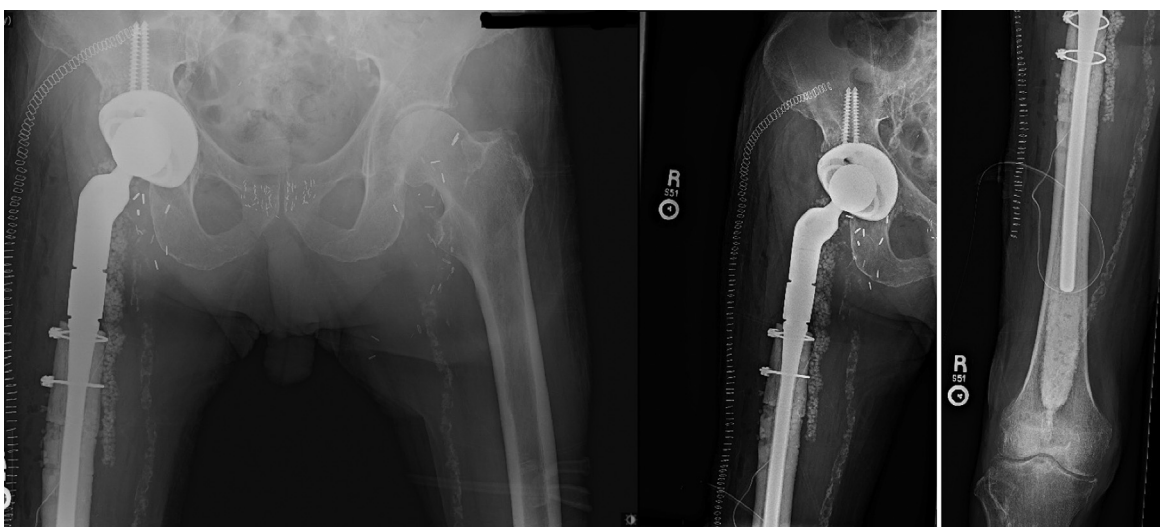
Postoperative radiographs showing patient now status-post replant proximal femoral replacement. Note extensive vascular calcifications.
